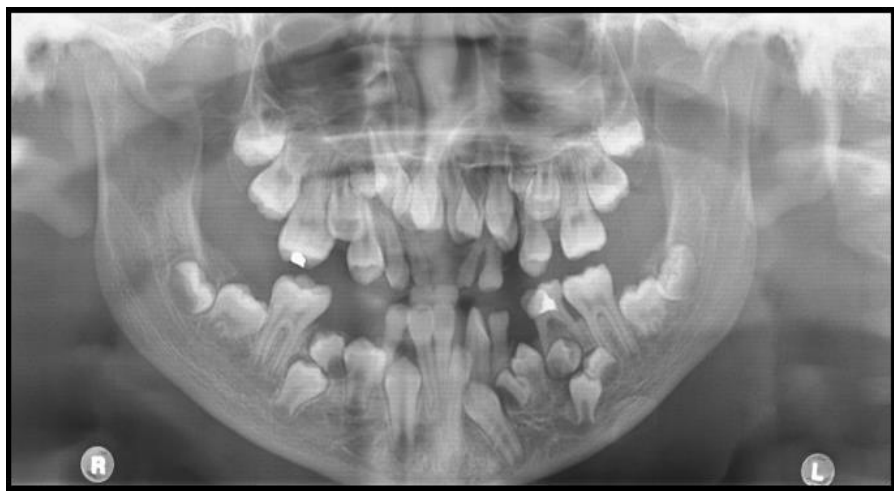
A panoramic radiograph showing multiple supernumeraries at the premolar region of all quadrants, and between 23 and 11 region.
